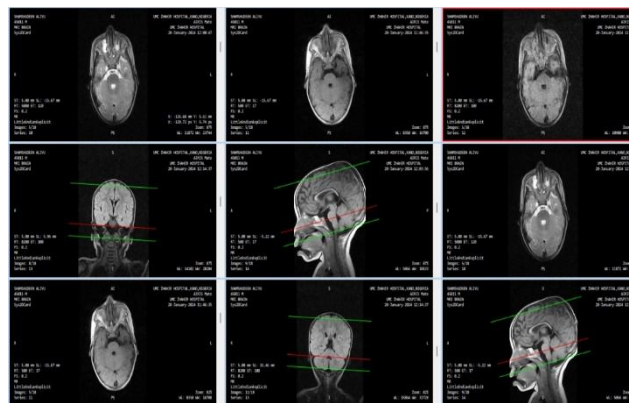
MRI Data set images
